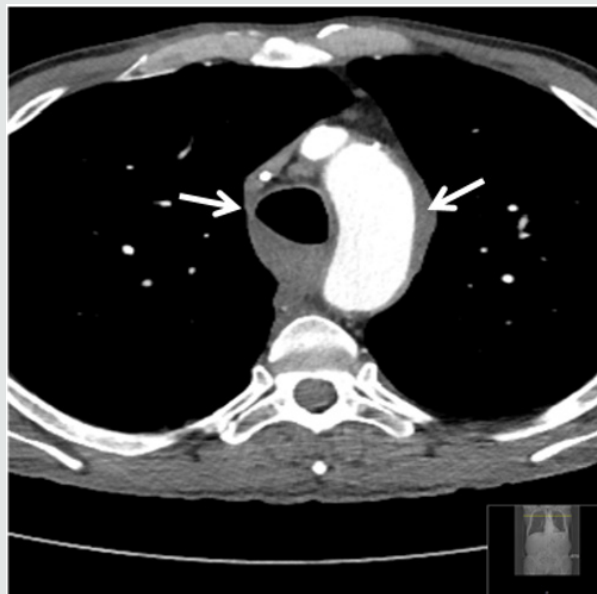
Follow-up Chest CT after removing the transesophageal pigtail showed almost complete necrosectomy of the mediastinal abscess. Pleural effusion also completely decreased on both sides.
